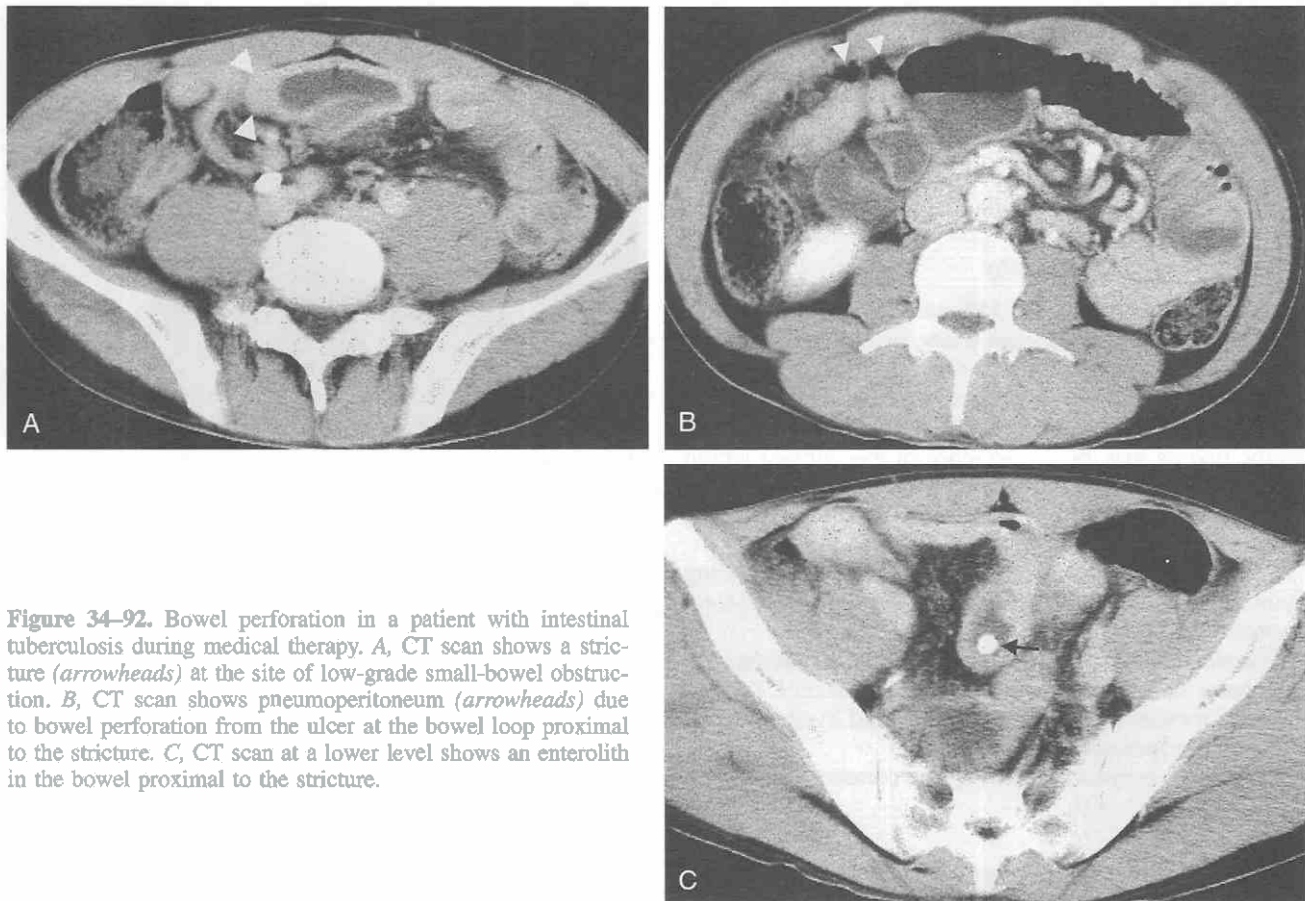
Bowel perforation in a patient with intestinal tuberculosis during medical therapy. *A*, CT scan shows a stricture (arrowheads) at the site of low-grade small-bowel obstruction. *B*, CT scan shows pneumoperitoneum (arrowheads) due to bowel perforation from the ulcer at the bowel loop proximal to the stricture. *C*, CT scan at a lower level shows an enterolith in the bowel proximal to the stricture.
